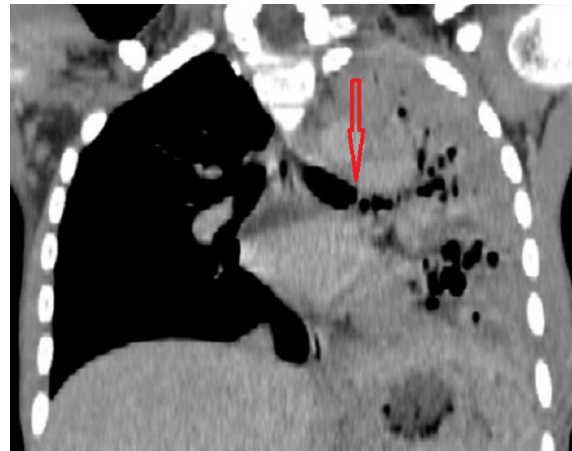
CT scan showing evidence of severe left lung parenchymal damage
